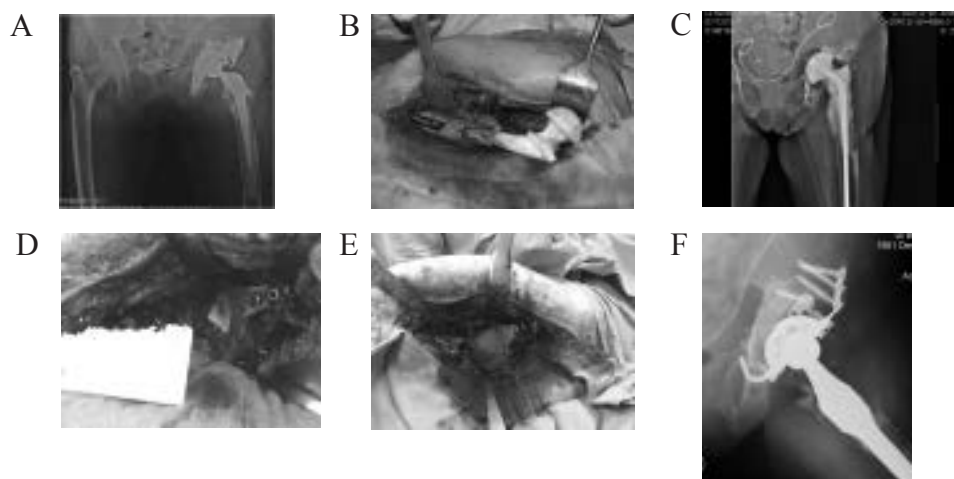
DBS, 52 years old caucasian female, peri-prosthetic infection in a cemented total hip arthroplasty, with extensive bone loss and after several previous surgeries and a previous renal transplant. Positive cultural examination (MRSA) and draining fistula. A): Pre-operative x-ray; B): Intra-operative picture at the time of infected implant removal and long stem spacer application; C): Post-operative x-ray; D, E): After 75 days the patients underwent spacer removal and bone stock reconstruction using antibiotic-loaded RegenOss and homologous morcellized bone graft to overcome large acetabular bone defect; F): Three years after surgery, radiographic findings show bone remodelling and bone stock reconstruction while the patient is infection free and able to walk long-distances with a cane.
